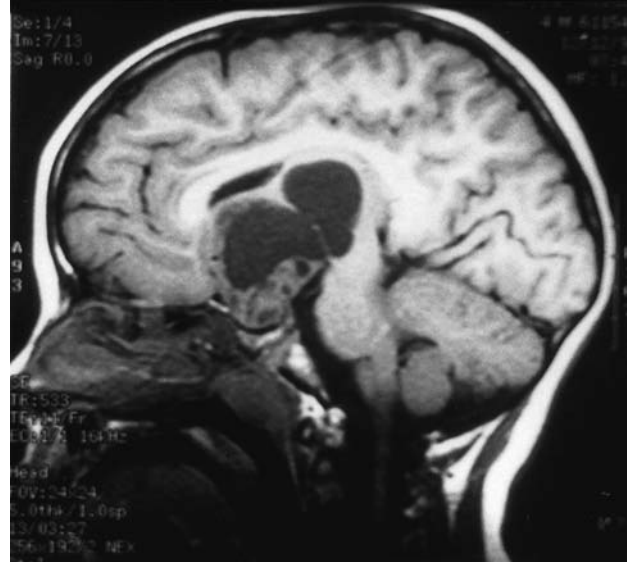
Midsagittal MRI showing a massive craniopharyngioma extending into the third ventricle from the sellar region through the disrupted floor of the third ventricle.
